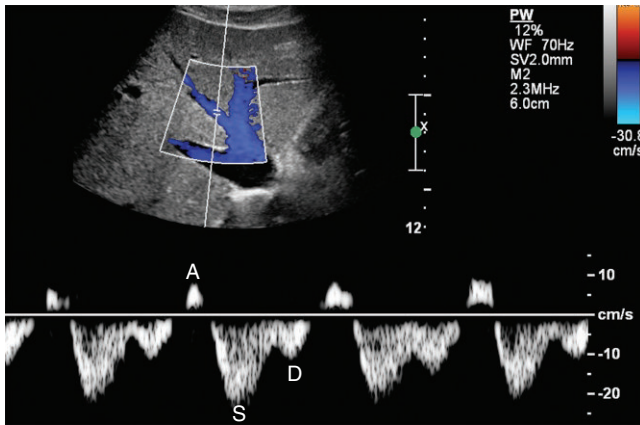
Spectral Doppler of normal middle hepatic vein. The normal hepatic vein waveform varies with the cardiac cycle. In the normal patient, during quiet breathing, there are three phases. Forward flow is seen in ventricular systole (S) and diastole (D). A transient reversal occurs during atrial systole (A). The absence of flow near the baseline is caused by the wall filter, which eliminates signals from the moving vessel wall and slow moving blood.
